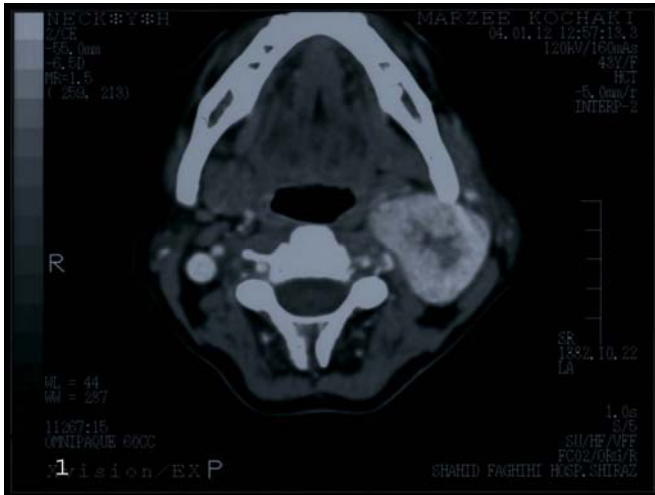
Computed tomography of the lesion, show the location of the tumor near carotid blood vessel.
